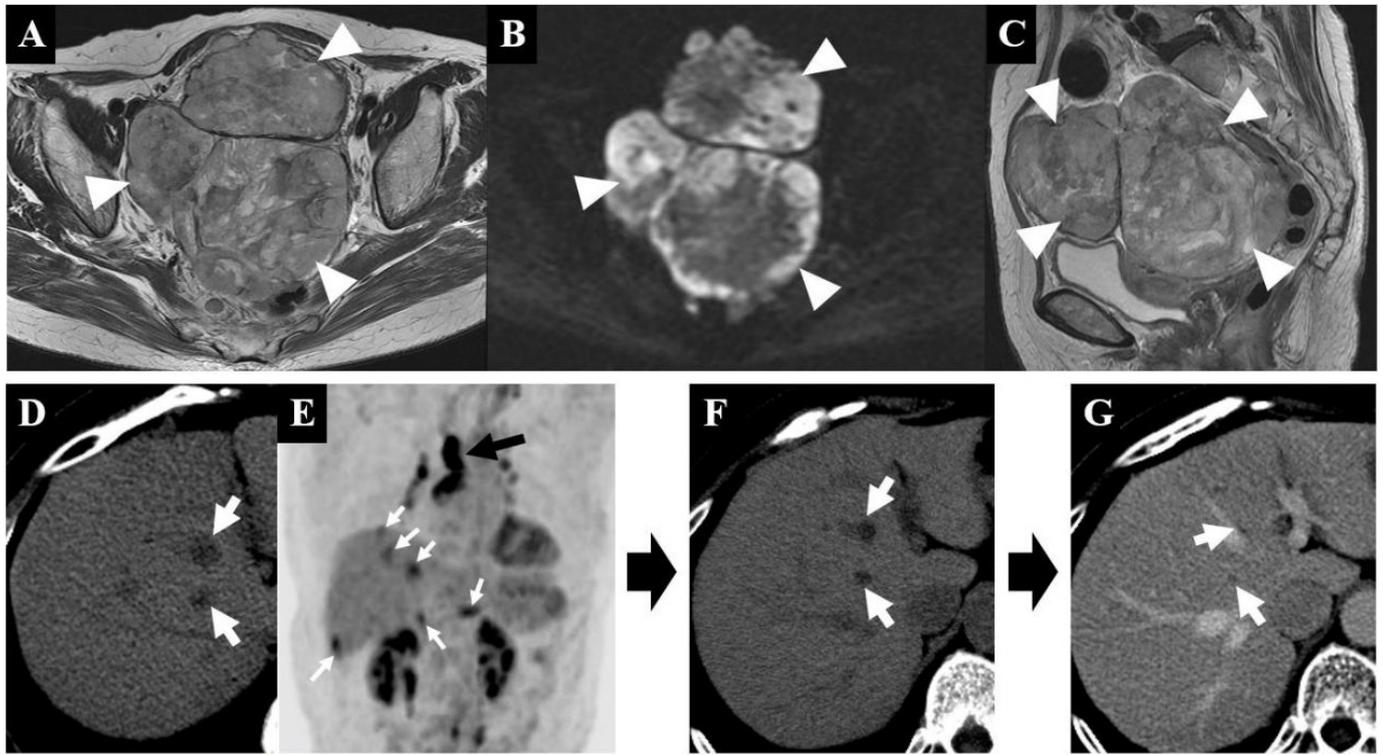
MRI, PET, and CT of liver and para-aortic lymph nodes metastases. (A–E) The preoperative images. (A–C) Magnetic resonance imaging (MRI) images showing a pelvic mass (White arrows) (A: T2WI axial; B: DWI axial; C: T2WI sagittal). (D–E) Fluorodeoxyglucose (FDG)-positron emission tomography (PET)/Computerized tomography (CT) images show hepatic metastases (white arrows) and para-aortic lymph node swelling (black arrow). (F–G) CT image of the course of treatment. The liver metastases are shrinking with treatment progression (F: Plain CT; G: Contrast-enhanced CT).
